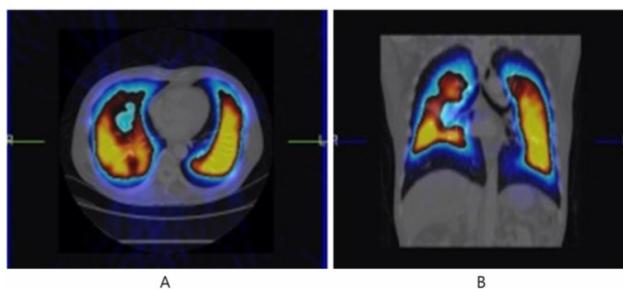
Lung fusion images (SPECT with CT), (A: transaxial, B: coronal)
